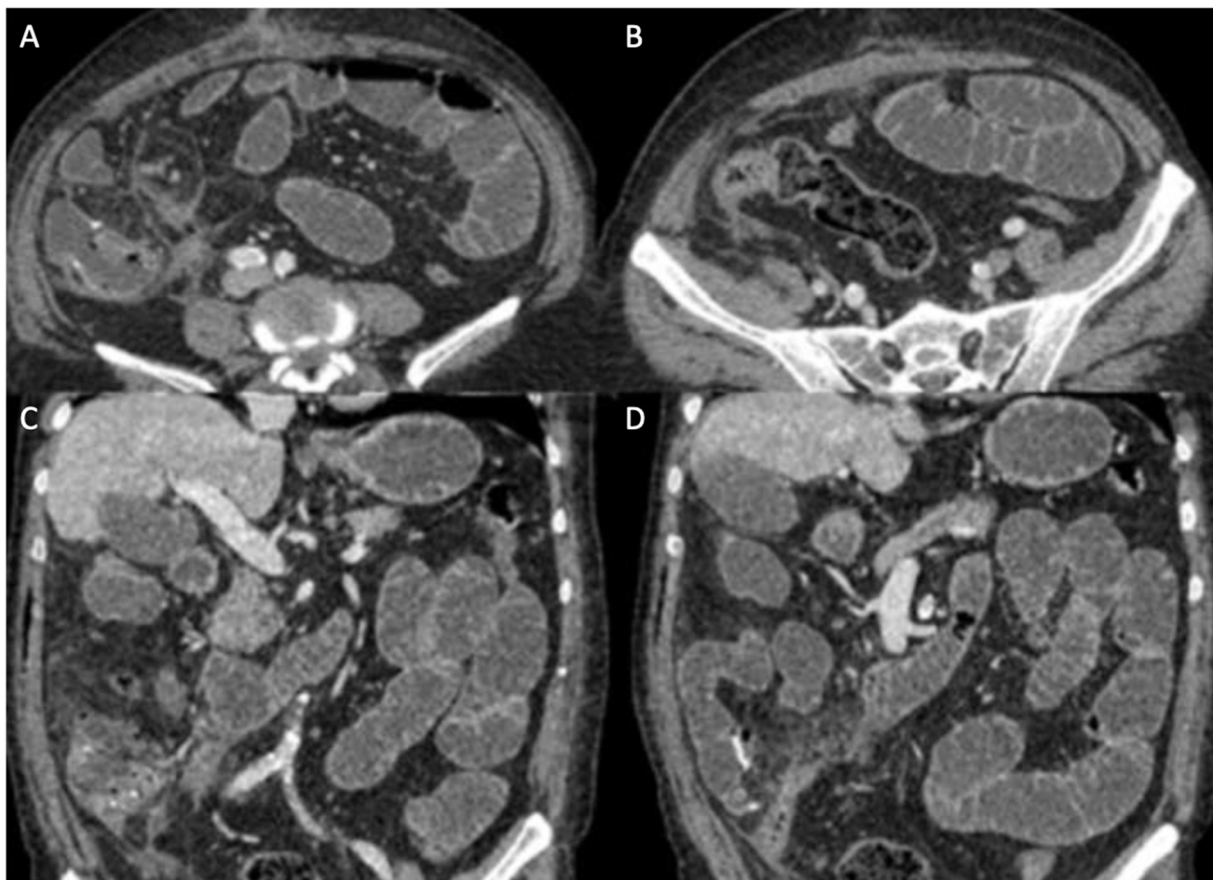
Control Abdominal CT scan images in axial (A, B) and coronal (C, D) after injection of contrast agent showing post-operative fat infiltration in the anastomosis area, no sign of residue or tumor recurrence in the short-term follow-up.
